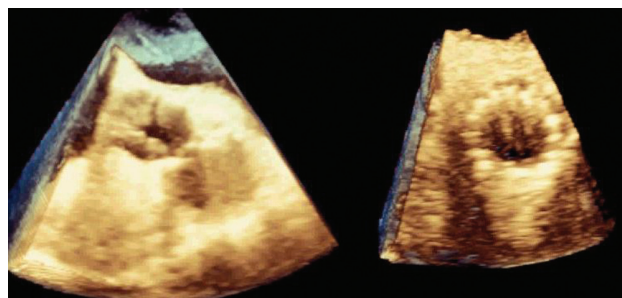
RT 3D TEE, short axis view in a patient undergoing TAVI. (a) pre, and (b) post implantation. RT 3D TEE = real time three-dimensional transesophageal echocardiography; TAVI = transcatheter aortic valve implantation.
